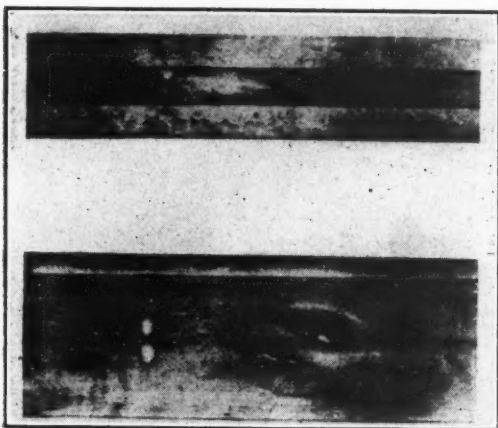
X-ray photograph showing front and side views of a laminated wooden spar of an aeroplane. The spar is made up of three laminæ glued together. The external appearance did not indicate that the middle layer contained two knots and a grub-hole and should not have been used.
